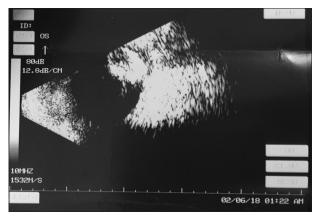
Ultrasound imaging of the left eye demonstrating an elliptic hyperdense finding in the inferior vitreous cavity adjacent to the retina, corresponding to a dropped crystalline lens
